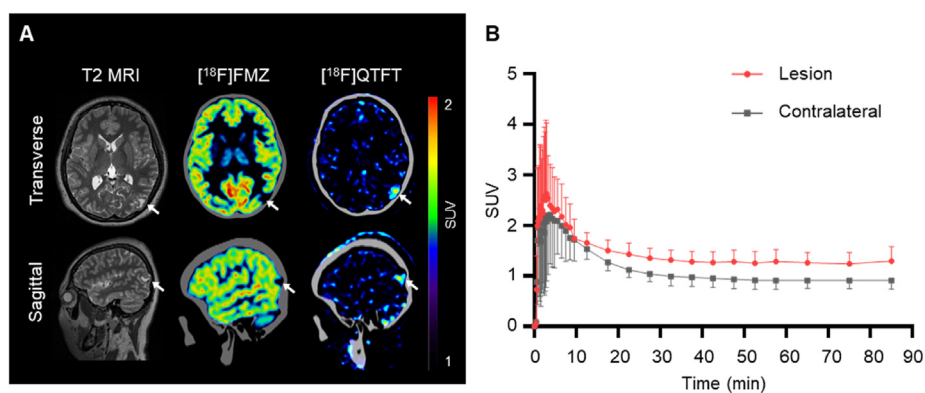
$[^{18}\text{F}]\text{QTFT}$ imaging epileptic foci in an epileptic patient. (A) $[^{18}\text{F}]\text{QTFT}$ PET imaging of a temporal lobe epilepsy patient at 90 min post intravenous administration. T2-weighted MR imaging and $[^{18}\text{F}]\text{FMZ}$ imaging confirm the location of epileptic foci. (B) Time-activity curves (TACs) of the epileptic lesion and contralateral normal brain after the administration of $[^{18}\text{F}]\text{QTFT}$. The data are shown as mean \pm SD.
